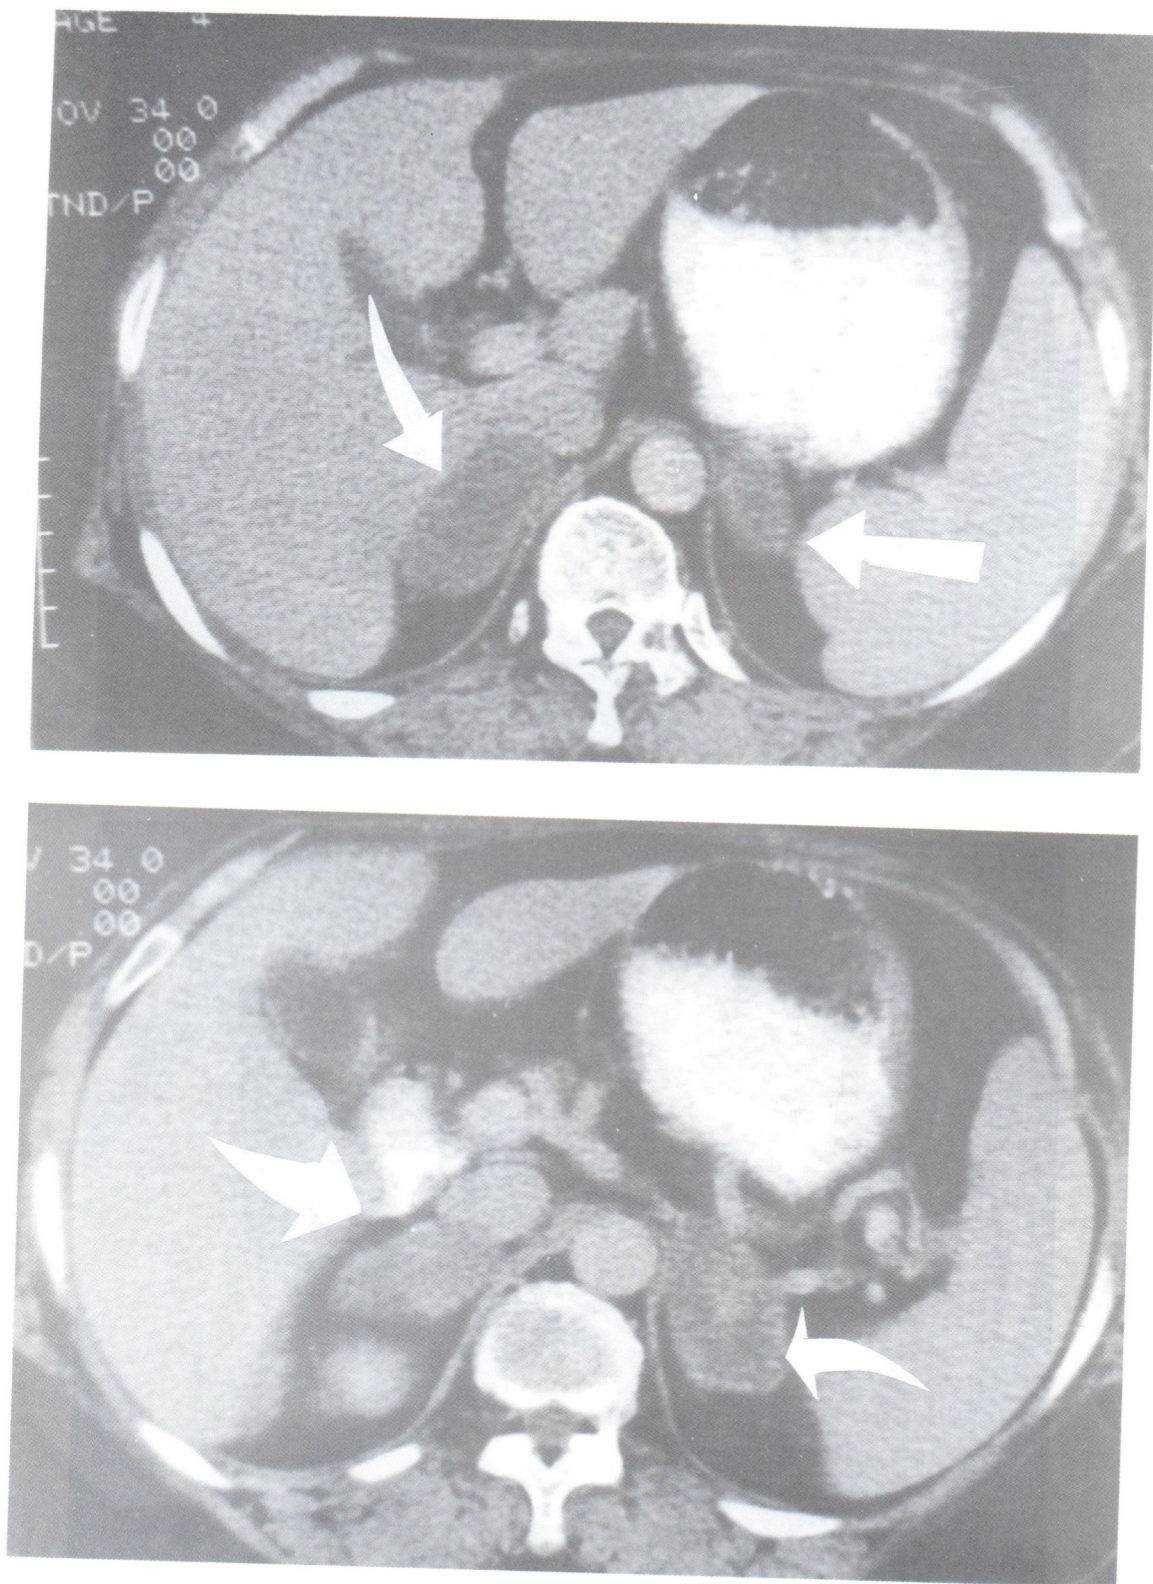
I.V. enhancement axial CT scan of the masses showed some faint internal enhancement of the masses.
